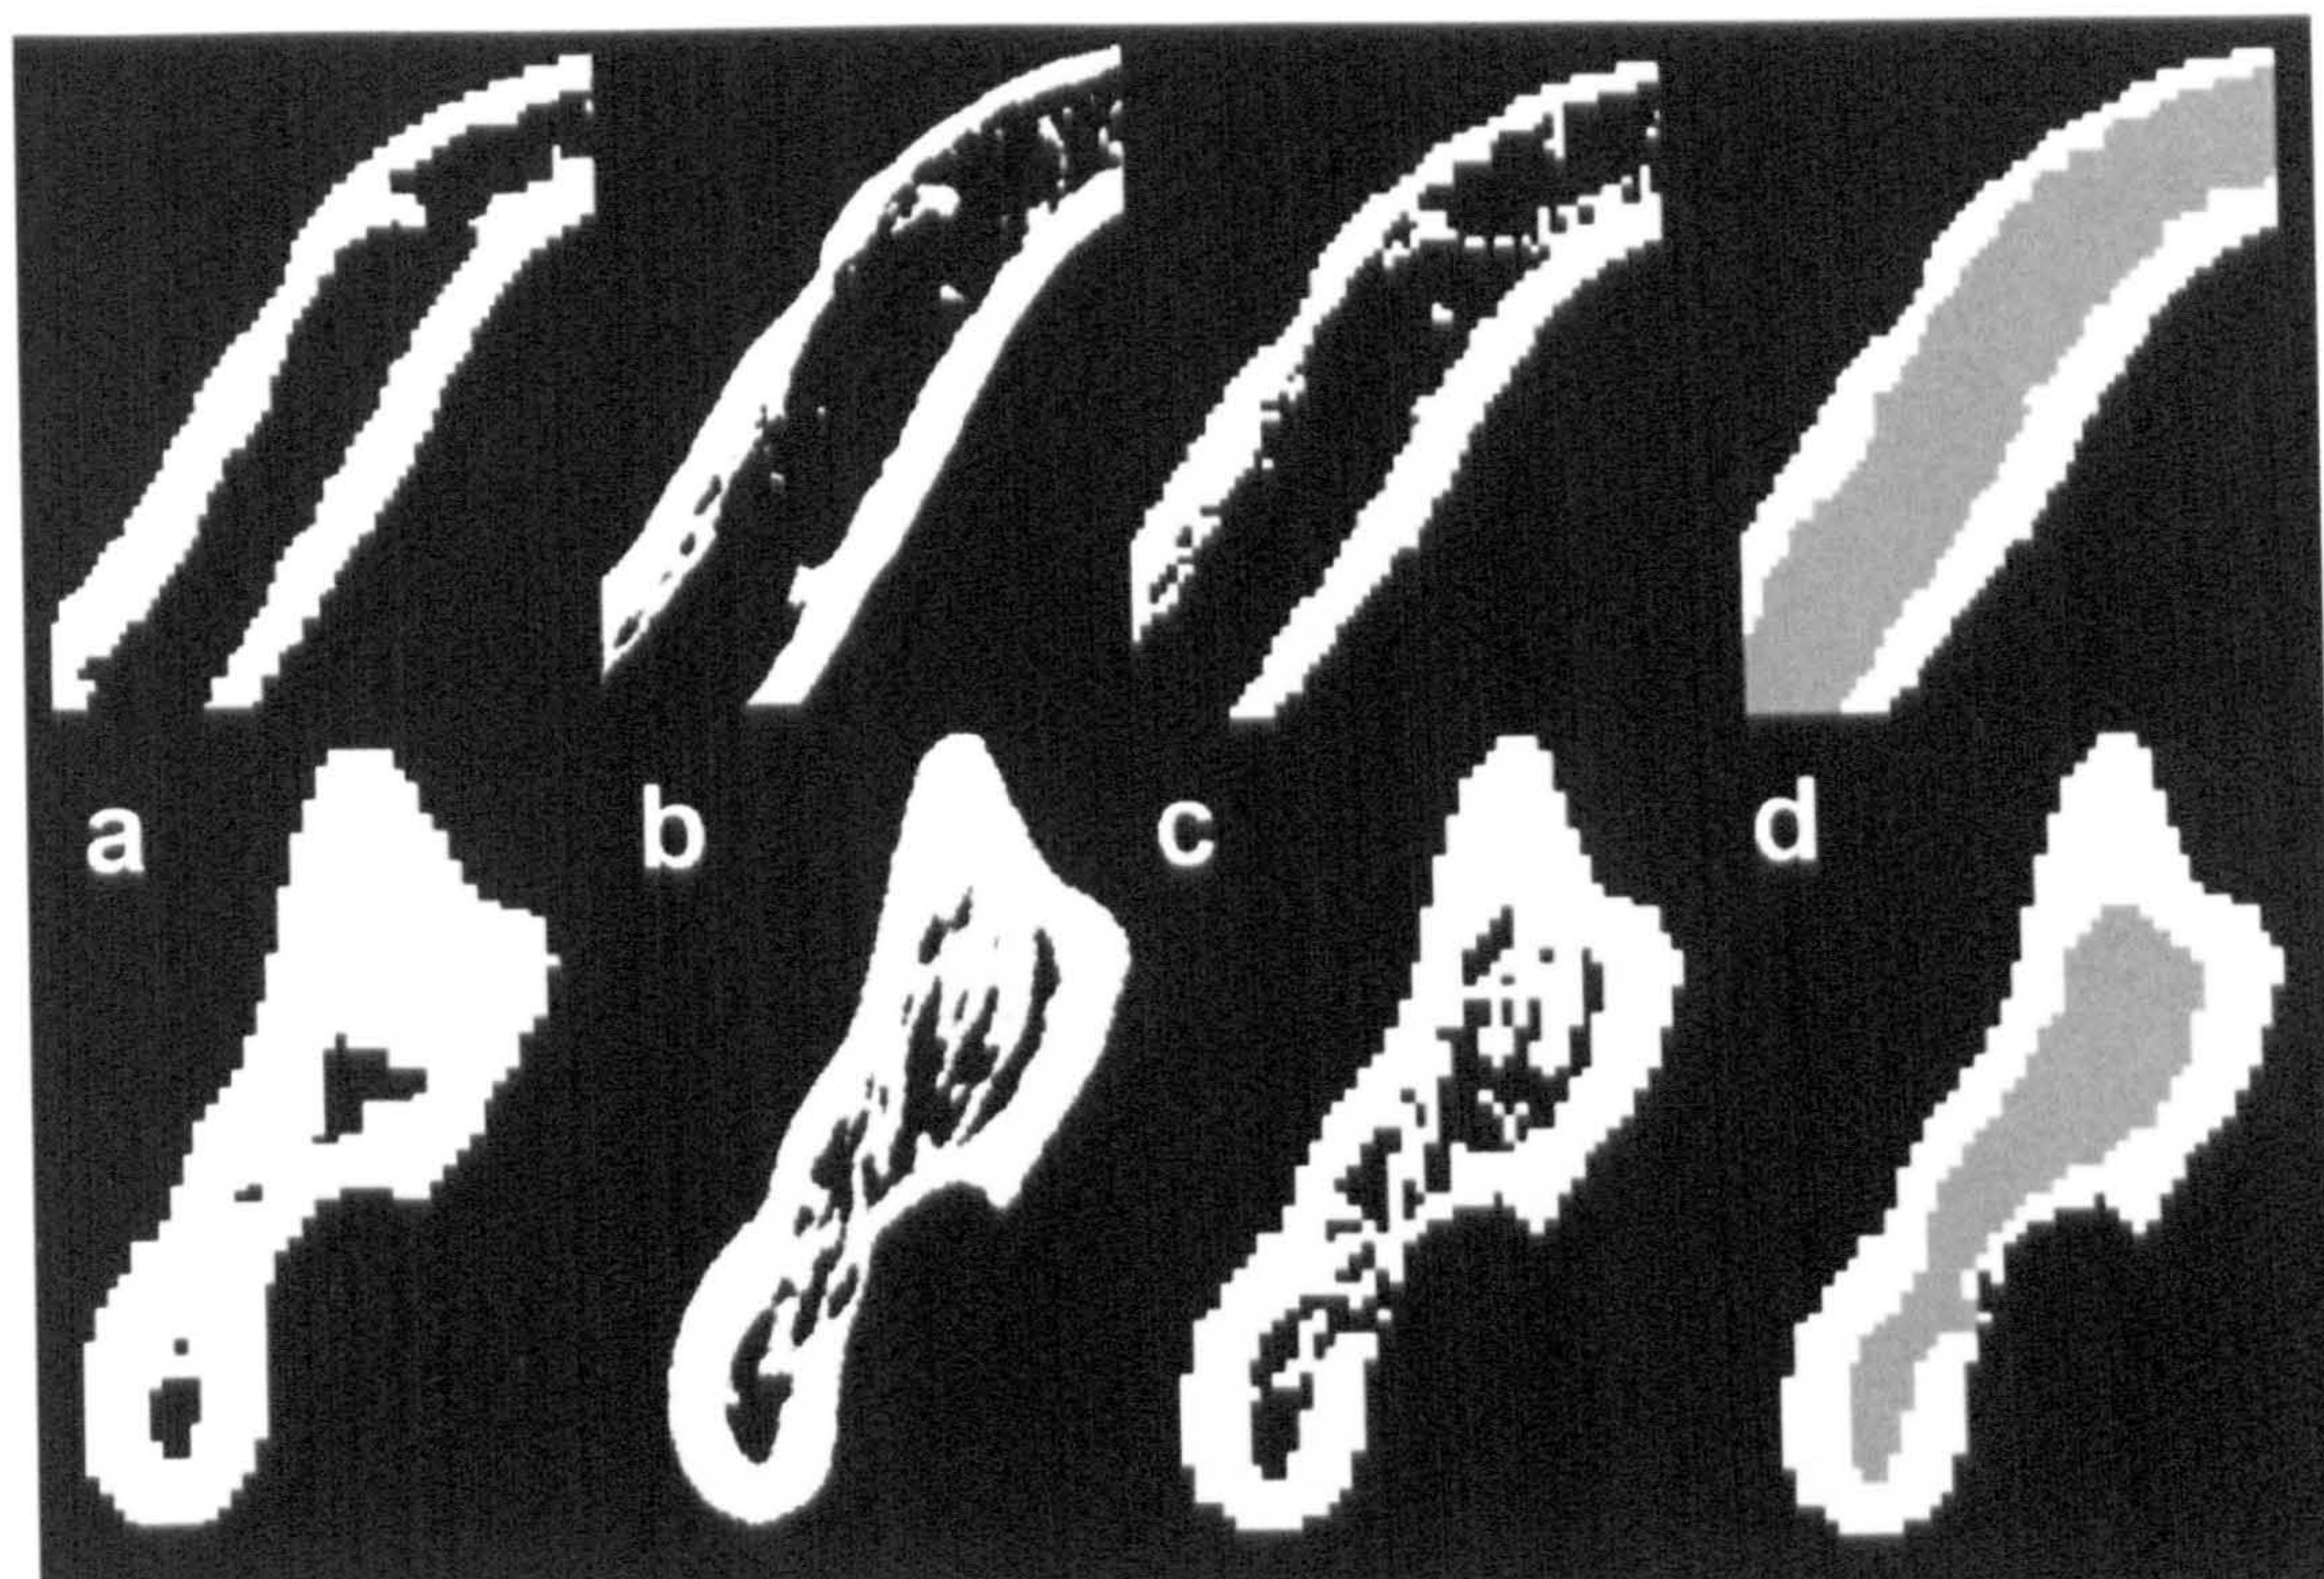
Transverse sections through the models at the height of the linear areas from which strain profiles were extracted (see Fig. 4.2). Upper row: sections through the mandibular corpus, bottom row: sections through the mandibular ramus. a) medical CT model, b) μ CT model, c) downsampled μ CT model, d) downsampled μ CT model with cancellous tissue as bulk material (grey).
